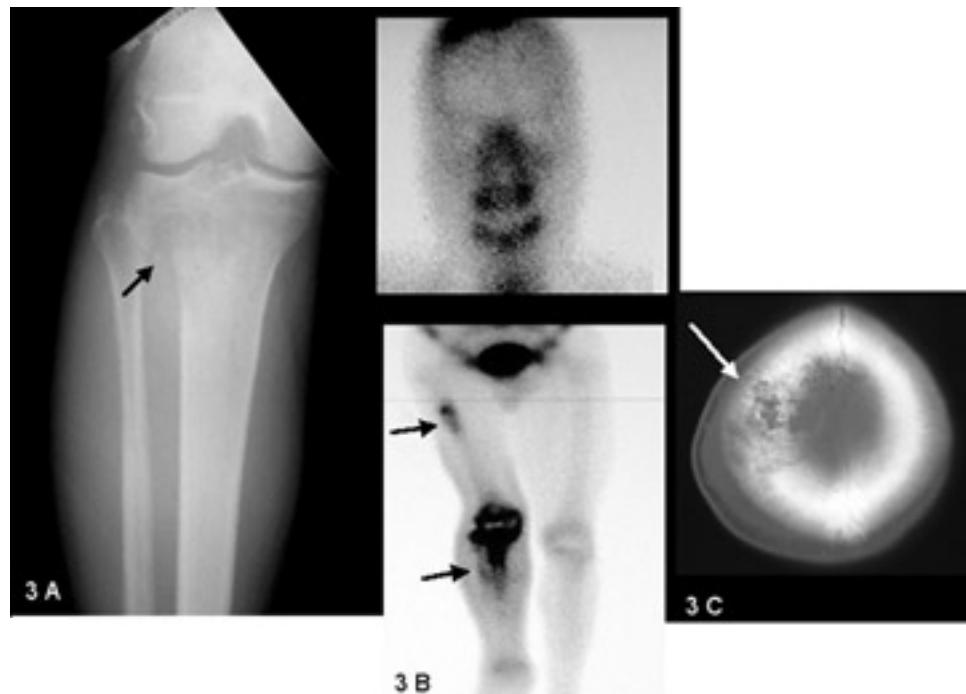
Twenty-six-year-old man with weight loss and fever. Multifocal bone non-Hodgkin's lymphoma. A. Right knee AP view. B. Bone scan. A poorly defined moth-eaten pattern is visible at the proximal metaphysis of the tibia. A lytic lesion with similar pattern is identified on the right parietal bone. Increased uptake in the skull, proximal shaft of the right femur, and right knee is clearly visible. C. CT of head. Bone window.
